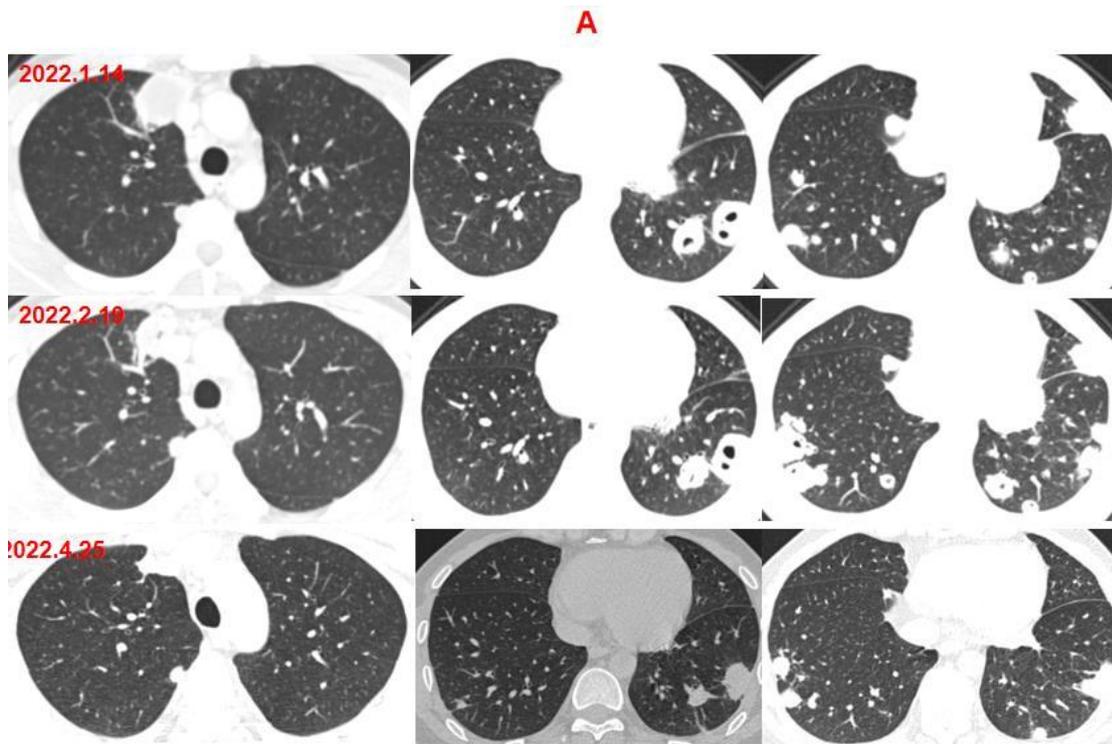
Comparison of chest CT before and after 3 months of treatment. A) Pulmonary window. B) Mediastinal window.
